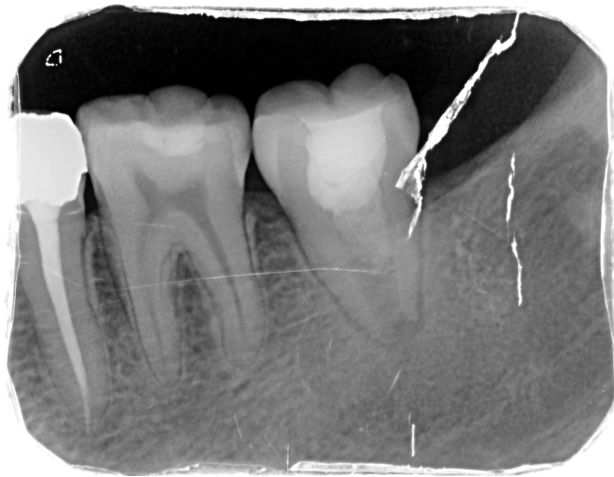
3-month follow-up radiograph
